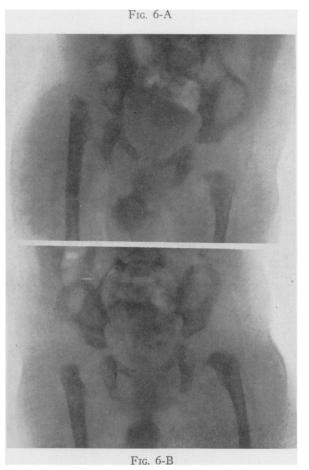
Roentgenogram of dislocated right hip as shown by displacement of femur laterally and upward. Telescoping, as shown by:
